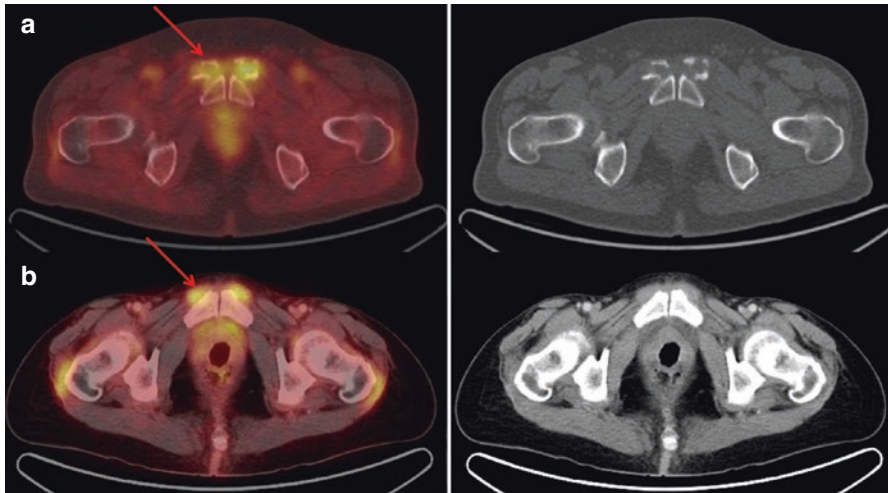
Axial slices with a positive prepubic findings in two different patients ((a) a 73-year-old man, (b) a 54-year-old woman) detected by FDG-PET/CT. FDG uptake hot spot in the fused image (left, arrow) corresponds to metabolically active inflammation in the insertions of the muscles located in front of the symphysis (pectineus, adductor longus muscle)
